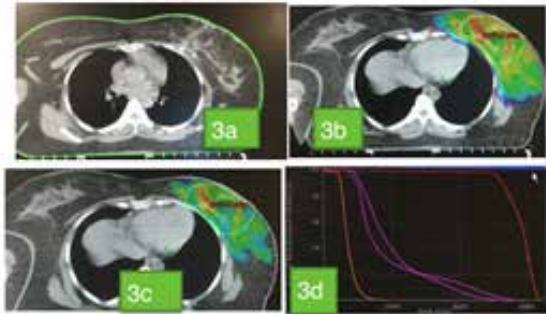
c&d: showing post op CT showing seroma cavity. b, c & d: radiotherapy planning including target delineations and dose to PTV 50 and PTV 60 Gy, DVH of lungs and heart.
